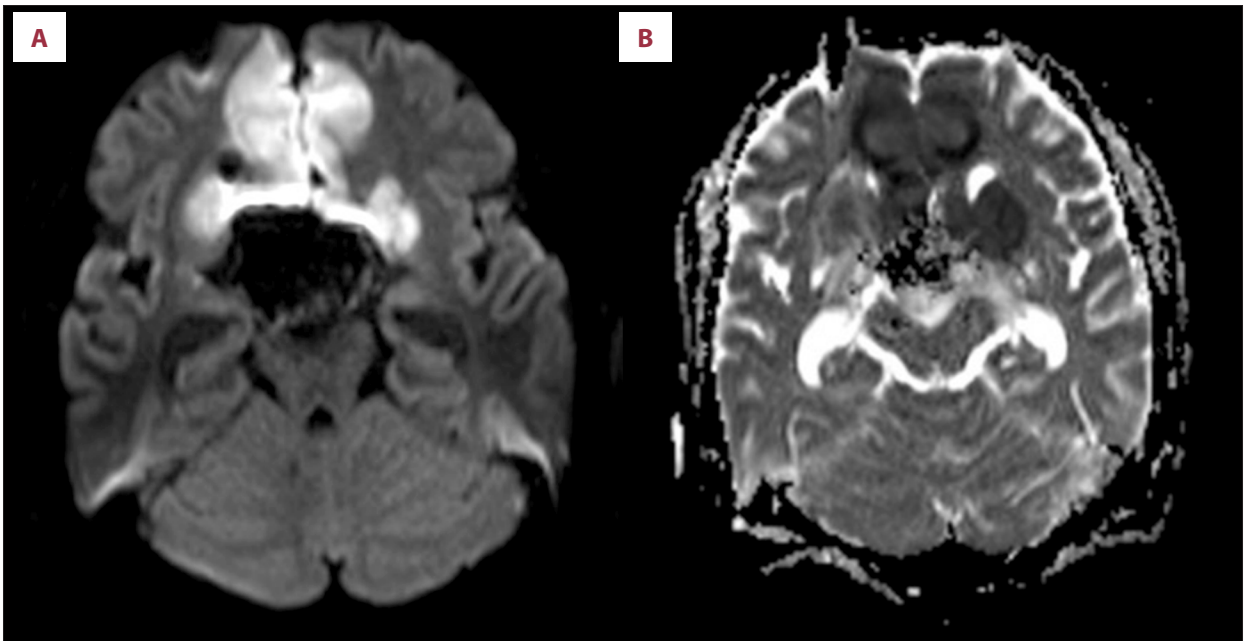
MRI DWI (A) and ADC map (B) images showing bilateral frontal parasagittal restricted diffusion bright signal in DWI and dark signal in ADC indicating underlying acute infarctions.
